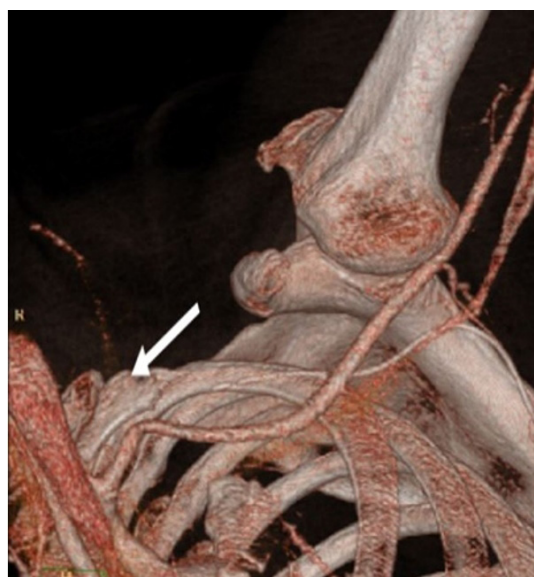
Computed tomography angiography demonstrating the resolution of stenosis in the left proximal subclavian artery and the resection of the first rib (arrow).
